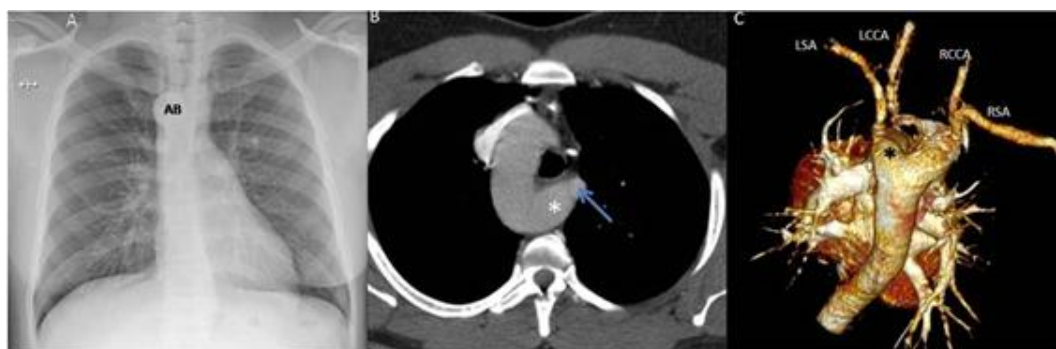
A. Posteroanterior (PA) chest radiograph revealing the right aortic button. B. Contrast-enhanced computed tomography (axial plane, mediastinal window) revealing the right aortic arch, Kommerell's diverticulum (asterisk), and aberrant left subclavian artery (arrow). C. Volume rendering (posterior view) confirms the diagnosis and reveals the emergence of the remaining supra-aortic vessels from the right aortic arch. AB - Aortic button; LCCA - Left common carotid artery; LSA - Left subclavian artery; RCCA - Right common carotid artery; RSA - Right subclavian artery.
